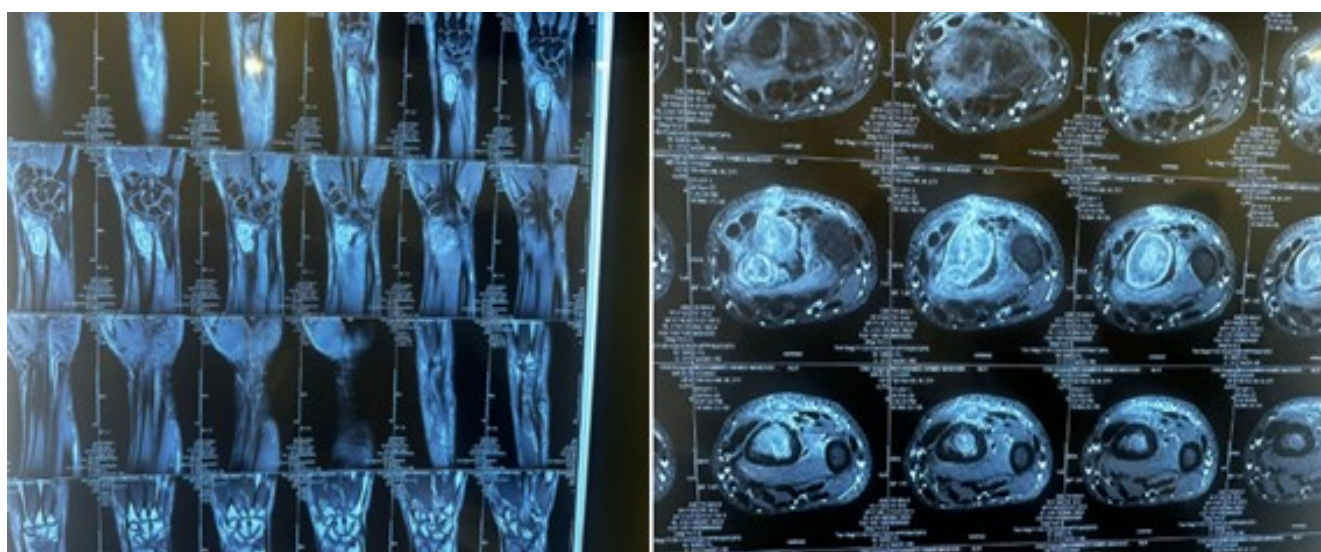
Pre-op MRI of Wrist Joint (Right side) showing the lesion
